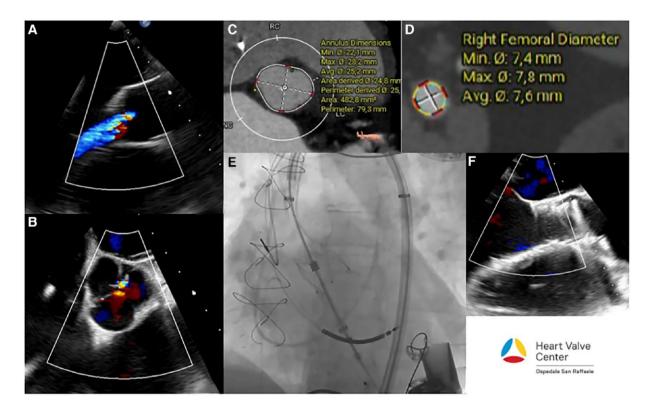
Percutaneous treatment of IA in a patient with an LVAD. We report the case of a patient treated with JenaValve with an LVAD. The patient (a 63-year-old man) visited our acute heart failure unit 4 years after LVAD implantation. Transthoracic echocardiogram (A, B) revealed severe IA. Given the prohibitive surgical risk, a transcatheter strategy was chosen. CT analysis showed a VBR perimeter of 79 mm and no evident valvular calcifications (C). Vascular access was adequate (>7.5 mm) (D). A JenaValve size L (27) was successfully implanted. (E) The post-operative course was free of adverse events and the patient was discharged home after 1 week in cardiocirculatory compensation. Pre-discharge echocardiogram showed minimal anterior peri-valvular leak (F).
